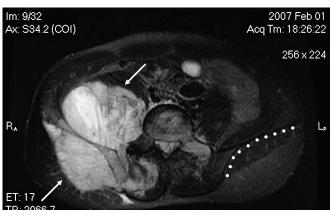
Magnetic resonance imaging of the pelvis at presentation demonstrating a 12.7-cm mass (arrows) consisting of massive soft-tissue extensions on both sides of the tumor epicenter in ilium. The dotted line indicates the external cortex of the uninvolved left ilium.
